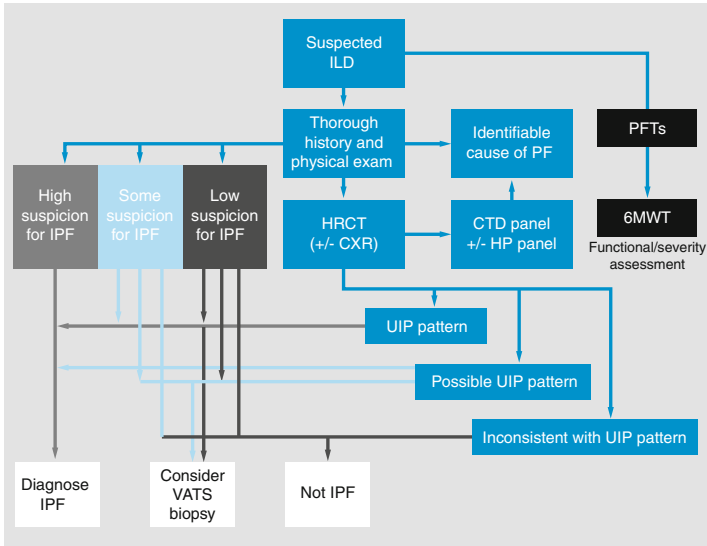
Diagnostic algorithm for idiopathic pulmonary fibrosis. *6MWT* 6-min walk test, *CTD* connective tissue disease, *CXR* chest X-ray, *HP* hypersensitivity pneumonitis, *HRCT* high resolution computed tomography, *ILD* interstitial lung disease, *IPF* idiopathic pulmonary fibrosis, *PFT* pulmonary function test, *UIP* usual interstitial pneumonia, *VATS* video-assisted thoracoscopic surgery
